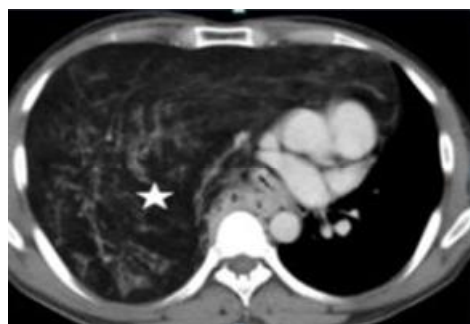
37-year old asymptomatic male diagnosed with mediastinal thymolipoma. CT scan-Post contrast axial view and reformatted coronal view of the chest in mediastinal window shows a large non enhancing fat containing mass lesion(asterisk) occupying the right hemithorax with extension into the anterior and posterior mediastinum and mild herniation into the contralateral hemithorax (curved arrow).Streaks of non enhancing soft tissues are seen within the lesion which represents thymic tissue (down arrow).
